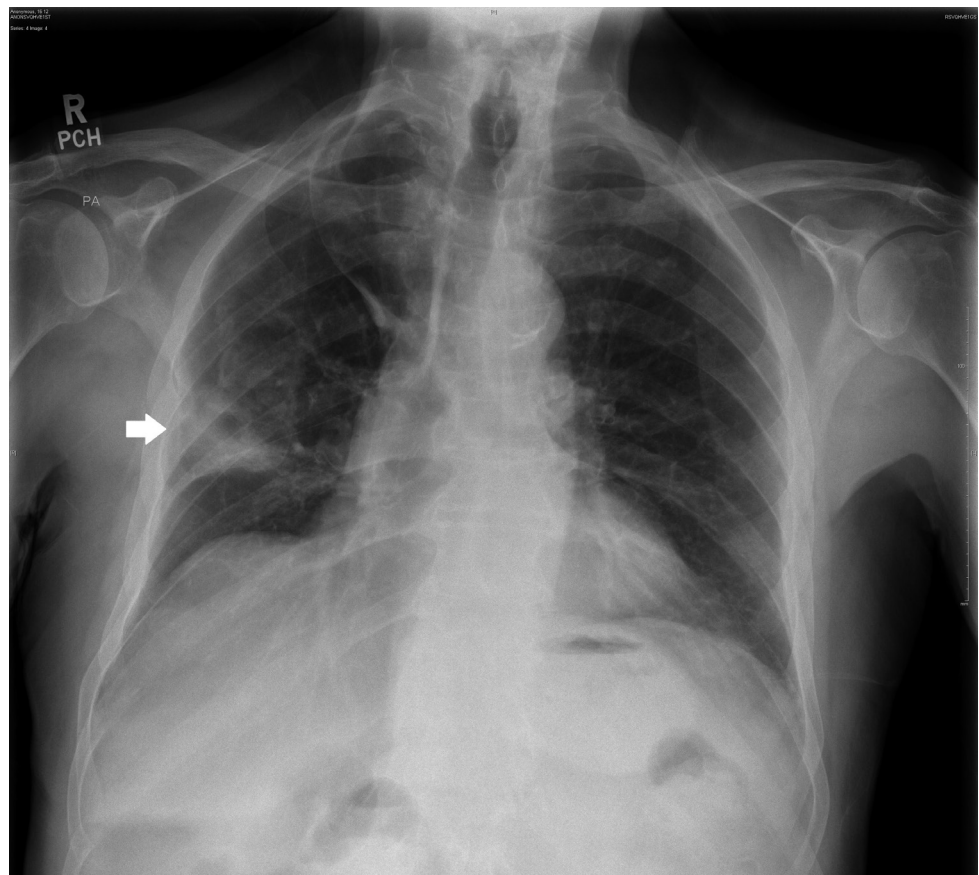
Chest radiograph taken 4 weeks post-discharge showing resolution of lung abscess and residual lung shadowing.
